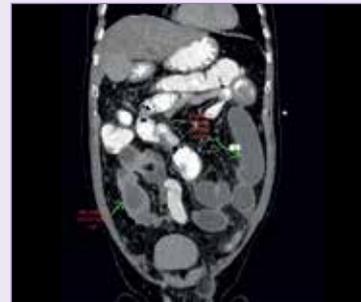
CORONAL CT image showing dilated small bowel loops, large Meckel's Diverticulum telescoping into ileal loops.
